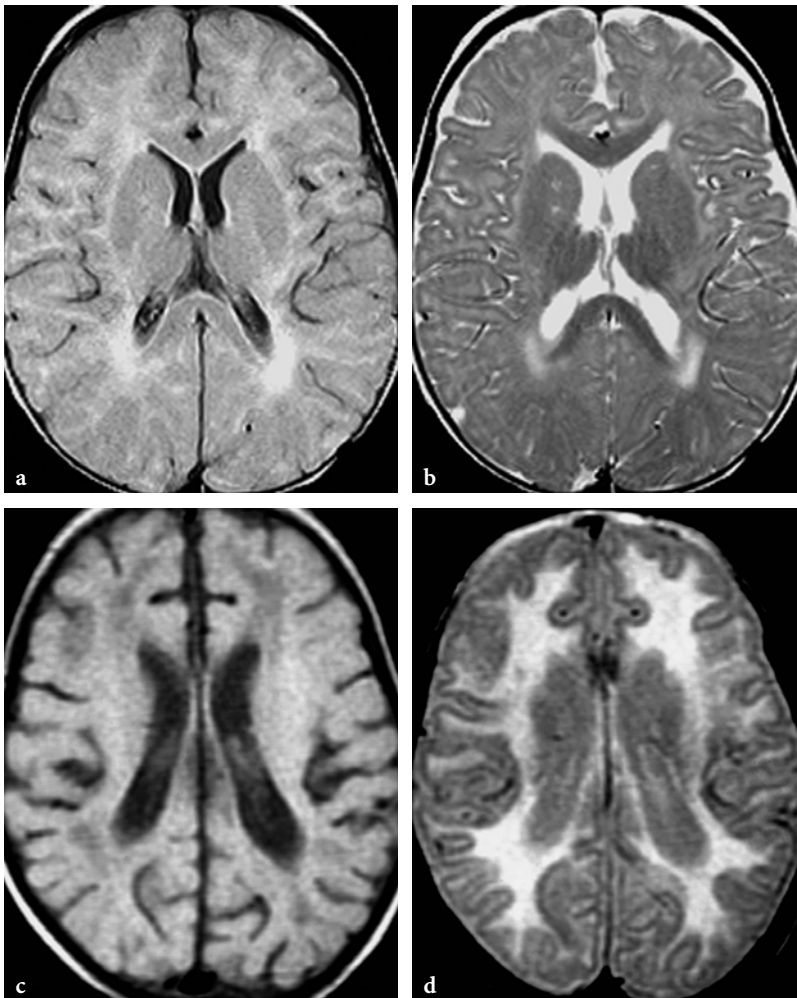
MR imaging findings in Aicardi-Goutières syndrome (courtesy of Dr. P. Tortori-Donati, Genoa, Italy). a, b. Axial FLAIR and T2-weighted fast spin-echo images in a 1-year-old patient (same as shown in Fig. 13.120a). The images show delayed myelination with early signs of demyelination. The corpus callosum is spared at this stage of disease. c, d. Axial T1-weighted spin-echo and T2-weighted fast spin-echo images in a 2-year-old patient (same as shown in Fig. 13.120b). The extensive demyelination within the cerebral hemispheres is better appreciated on the T2-weighted image
